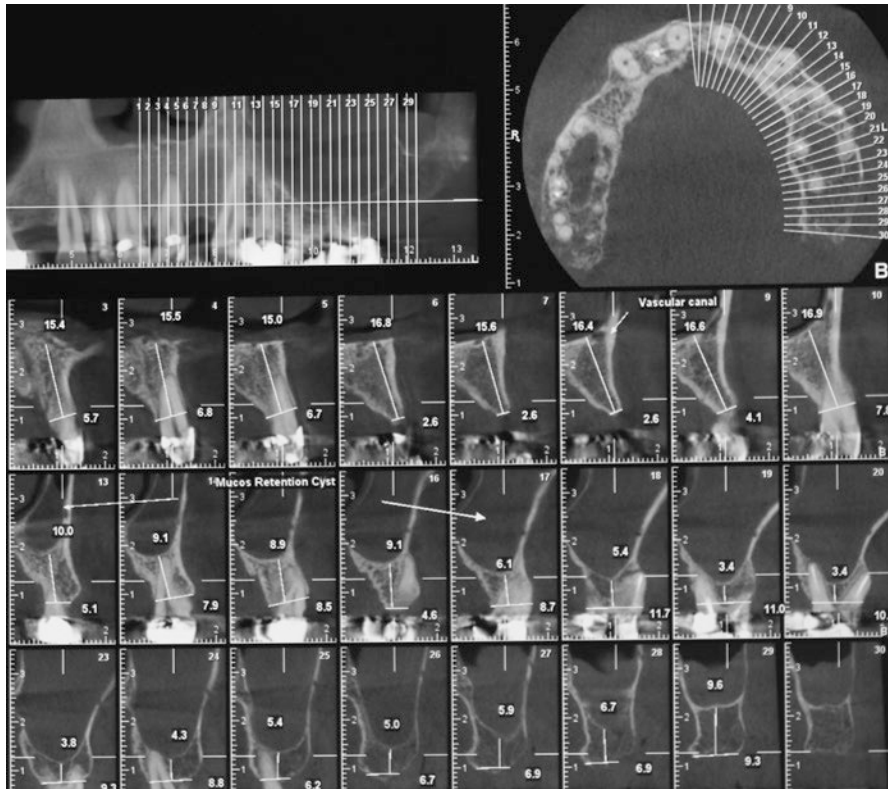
Maxillary sinus mucous cyst in the left antrum shown in the pre-op CBCT
